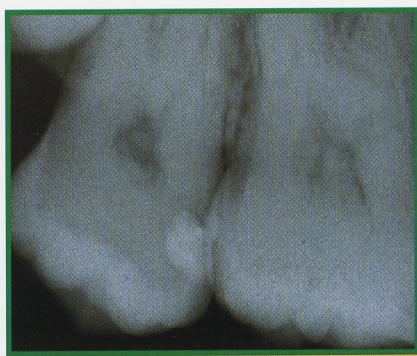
Radiograph of the completed restoration.
